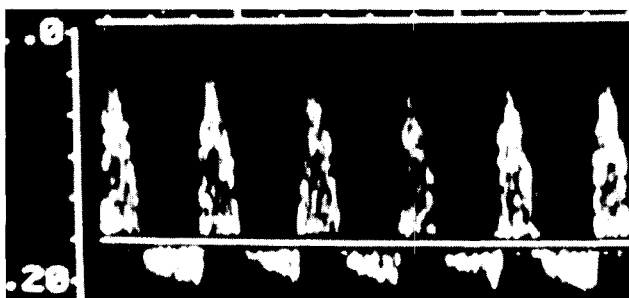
Case 10: pulsed Doppler ultrasound reveals an abnormal waveform, with reversed diastolic velocities, into the middle cerebral artery supplying the porencephalic hemisphere. The contralateral artery had normal velocimetry
